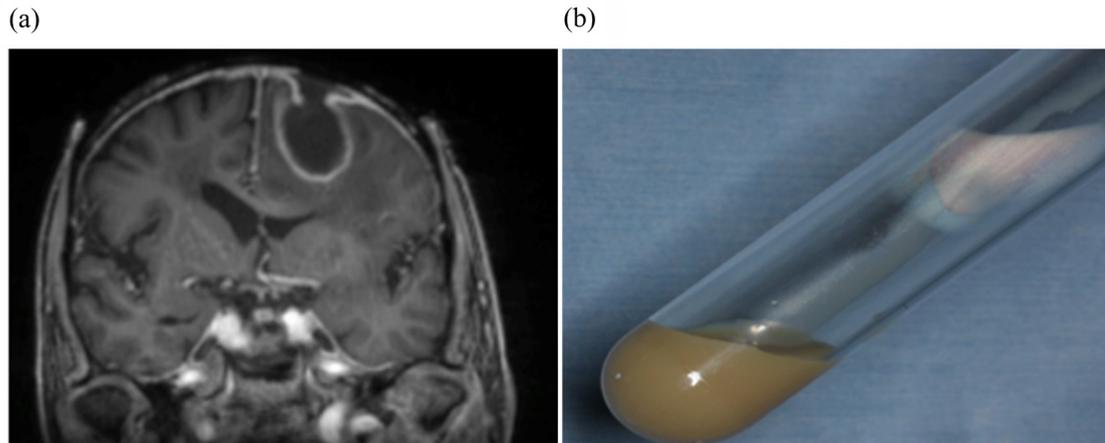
(a) Brain magnetic resonance imaging showing a 50-mm ring-enhancing lesion in the left frontal lobe. (b) Emergency drainage of brain abscess revealed yellowish-white viscous fluid.
